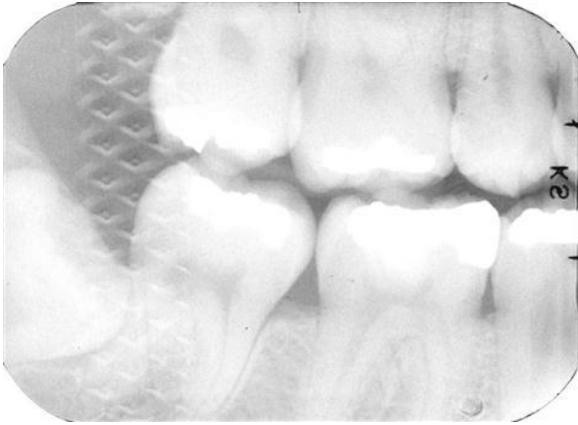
Placing a film backward in the patient's mouth when the exposure was made results in a radiograph that is too light and shows the characteristic markings caused by exposure through the lead foil in the film packaging. In such an image, the left and right sides of the patient are reversed when using the dot as the orientation guide.
